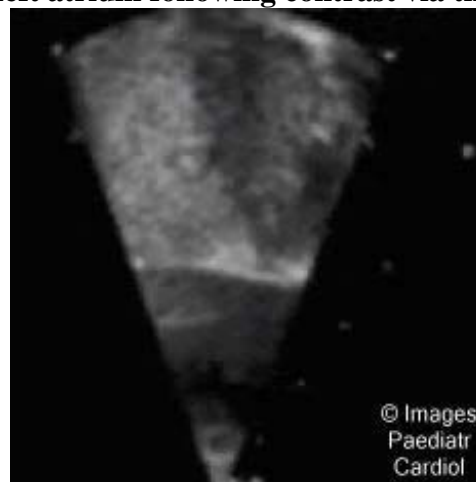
Subcostal view of echocardiographic contrast study showing the rapid filling of the left atrium following contrast via the right atrium
